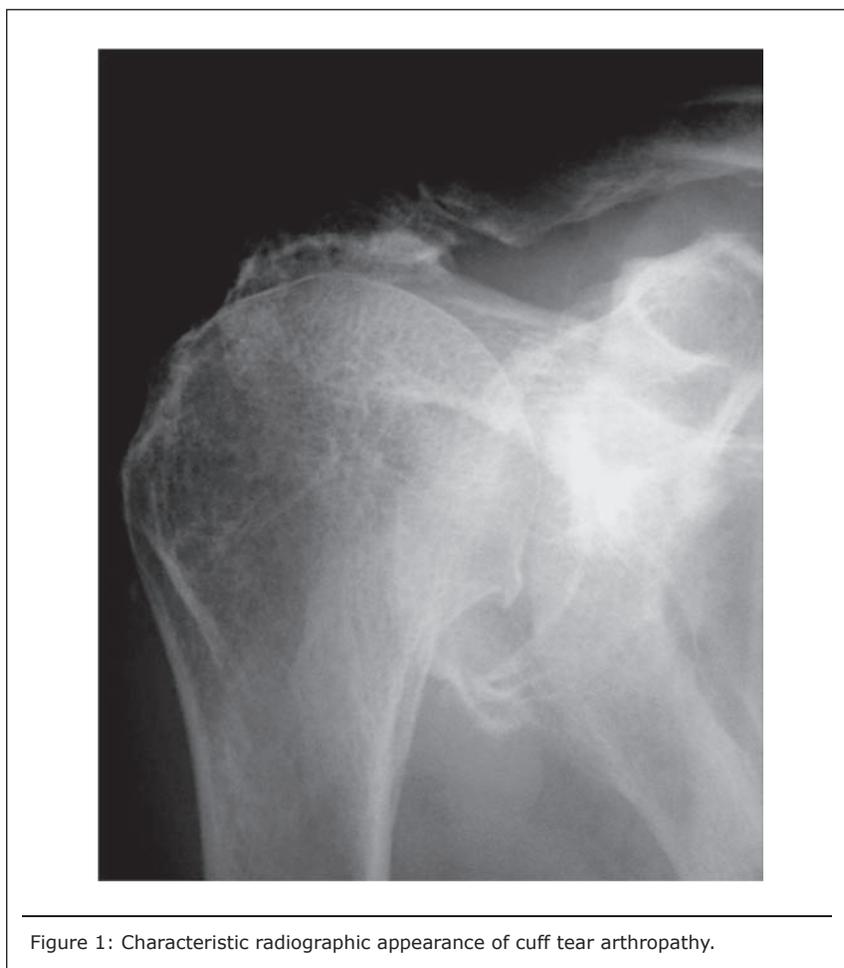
Characteristic radiographic appearance of cuff tear arthropathy.
